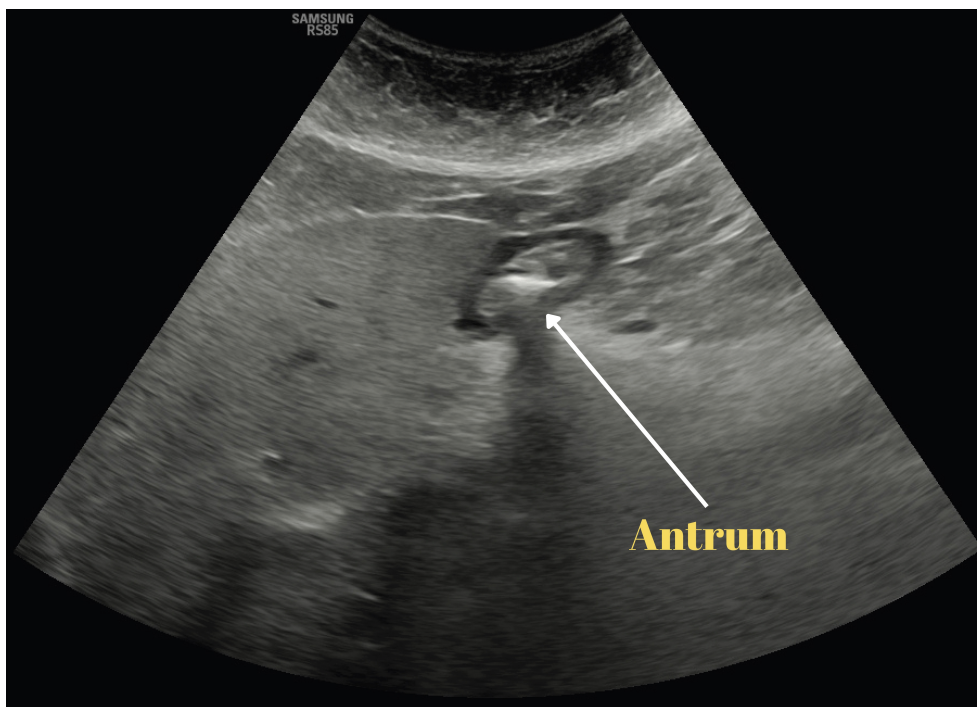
Ultrasound image of the gastric antrum in the right lateral decubitus position. Representative image of the gastric antrum obtained via ultrasonography, demonstrating the anatomical borders of the antrum in the right lateral decubitus position.
